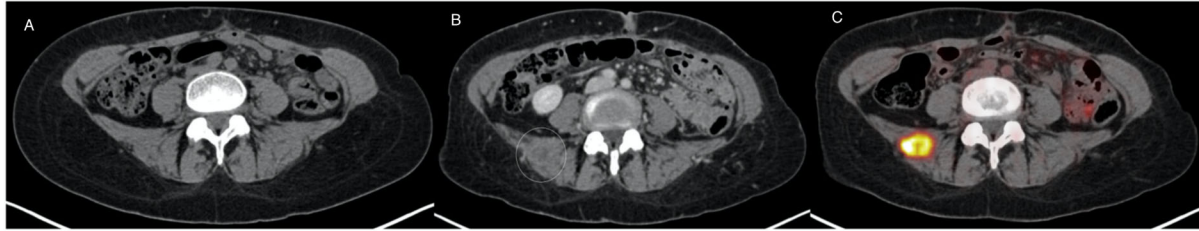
In a patient with Hodgkin lymphoma, UECT did not detect the lesion in the right paravertebral muscles (A) revealed as a hypovascular nodular area (circle) by CECT (B), thereby indicating Ann Arbor stage III instead of stage IV suggested by CECT; the corresponding hyper-metabolic lesion evident on FDG-PET (C).
